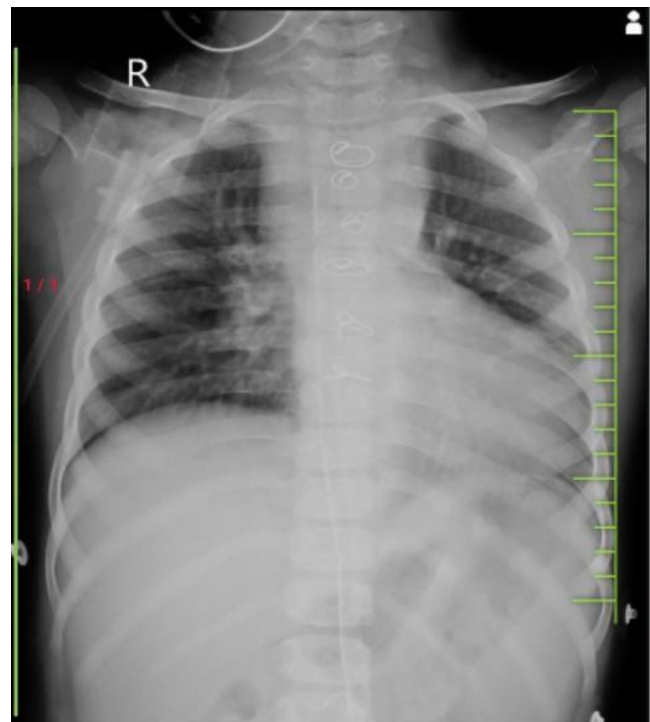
Chest Radiography
